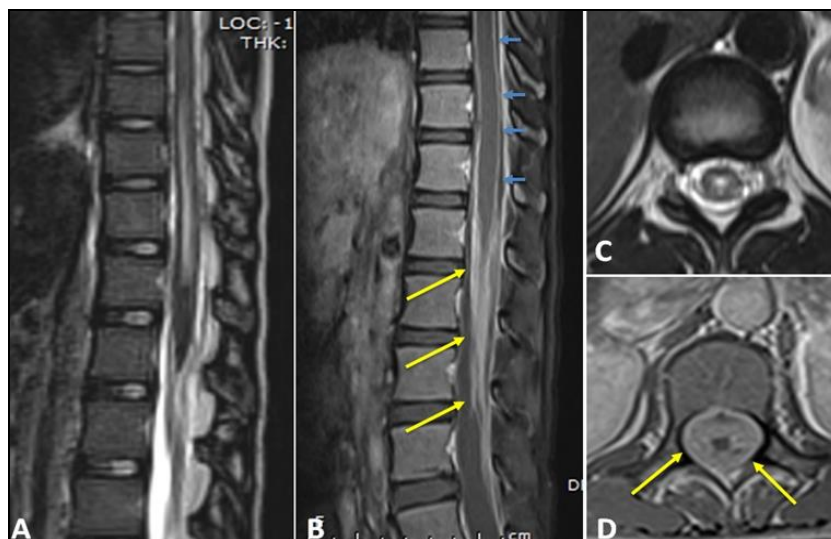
Tubercular myelopathy: Sagittal T2W (A) MRI image shows long segment T2 hyperintense signal changes in lower dorsal cord from D9 to D12 vertebral levels. T2 axial (C) image shows holocord involvement. No evidence of cord expansion seen. Post Gd-T1FS Sagittal and axial images (B, D) show thickened, clumped and enhancing cauda equina nerve roots suggesting arachnoiditis (yellow arrows). There is also enhancement along the surface of the spinal cord suggesting lepto-meningeal enhancement (short blue arrows)
